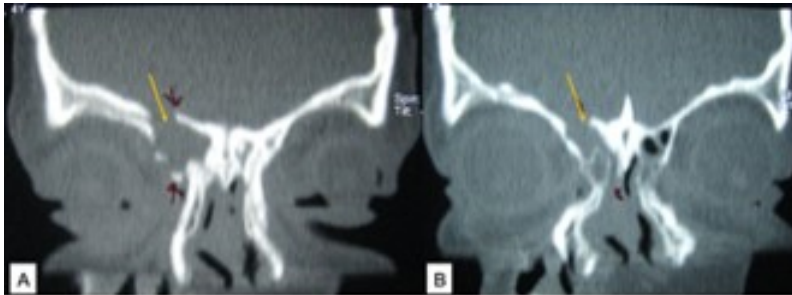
(A,B) CT scan of anterior skull base (coronal images) in bony window, showing traumatic fractures resulting in a CSF fistula through the ethmoid sinus (arrow marked). Source: Figure by authors.
